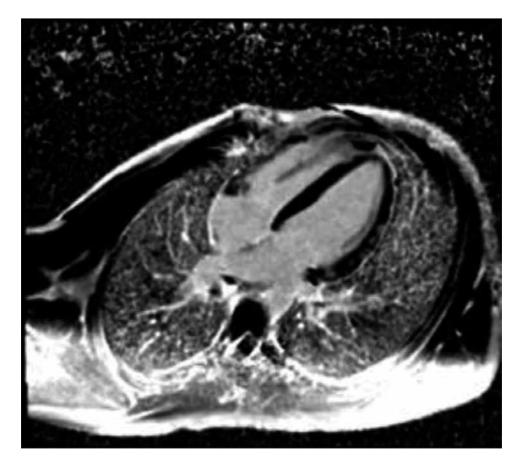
Cardiac MRI demonstrating scar and fibrosis using a late gadolinium enhancement technique.
